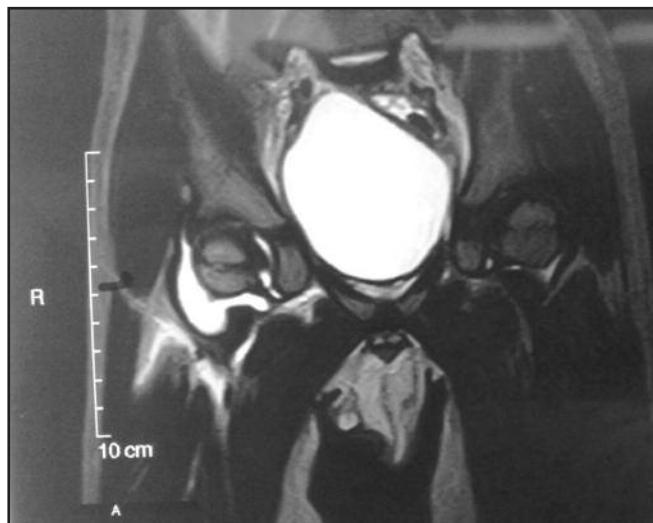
MRI of right Hip showed effusion due to septic arthritis
